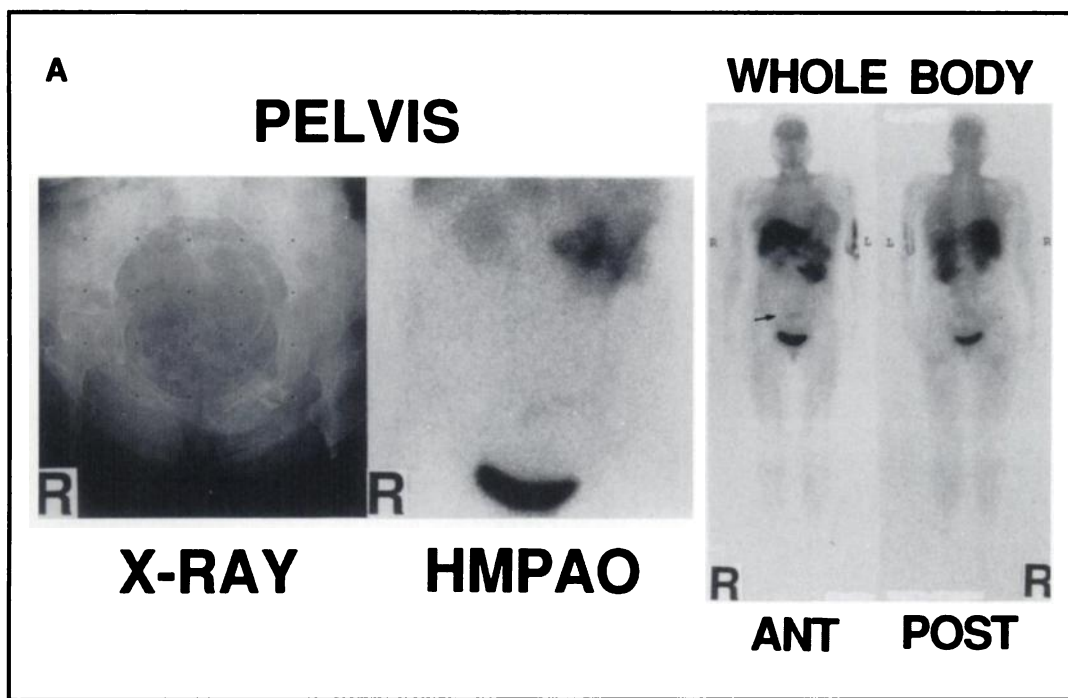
(Right) Whole-body ^{99m}Tc -HMPAO images reveal focal uptake in the pelvis. (Left) Pelvic radiography was the only source of irradiation other than brain SPECT to which the patient was exposed during her pregnancy. Anterior abdominal ^{99m}Tc -HMPAO image reveals uptake in the fetal liver (\uparrow).
